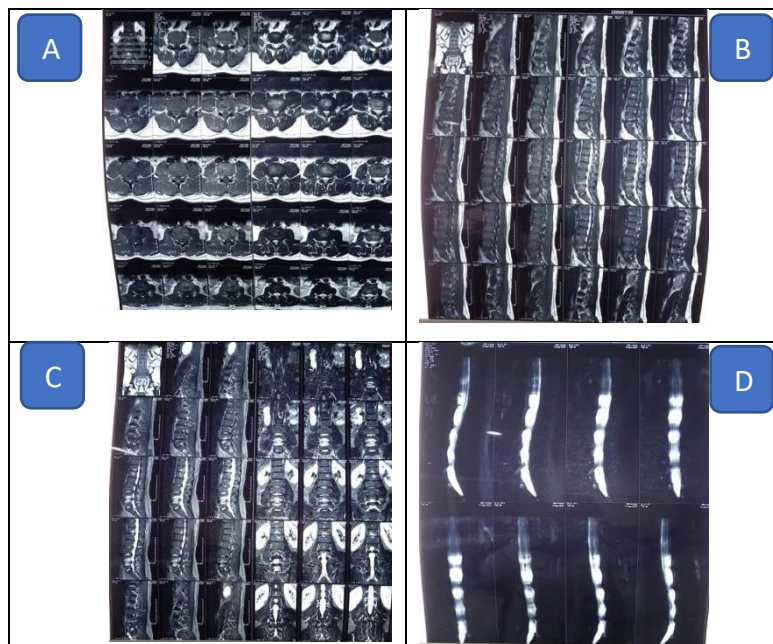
MRI examination results. (A) MRI axial sections of T1 and T2; (B) T1 sagittal section; (C) MRI T2; (d) T2 section.
